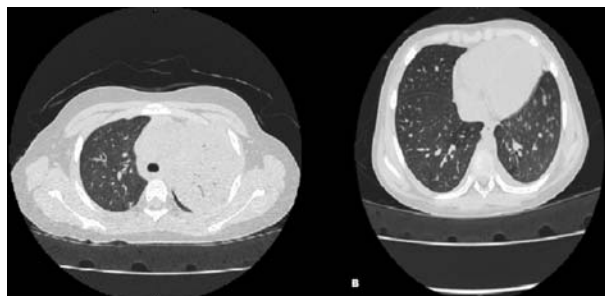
Image showing HRCT chest before (a) and one month after (b) induction chemotherapy.
